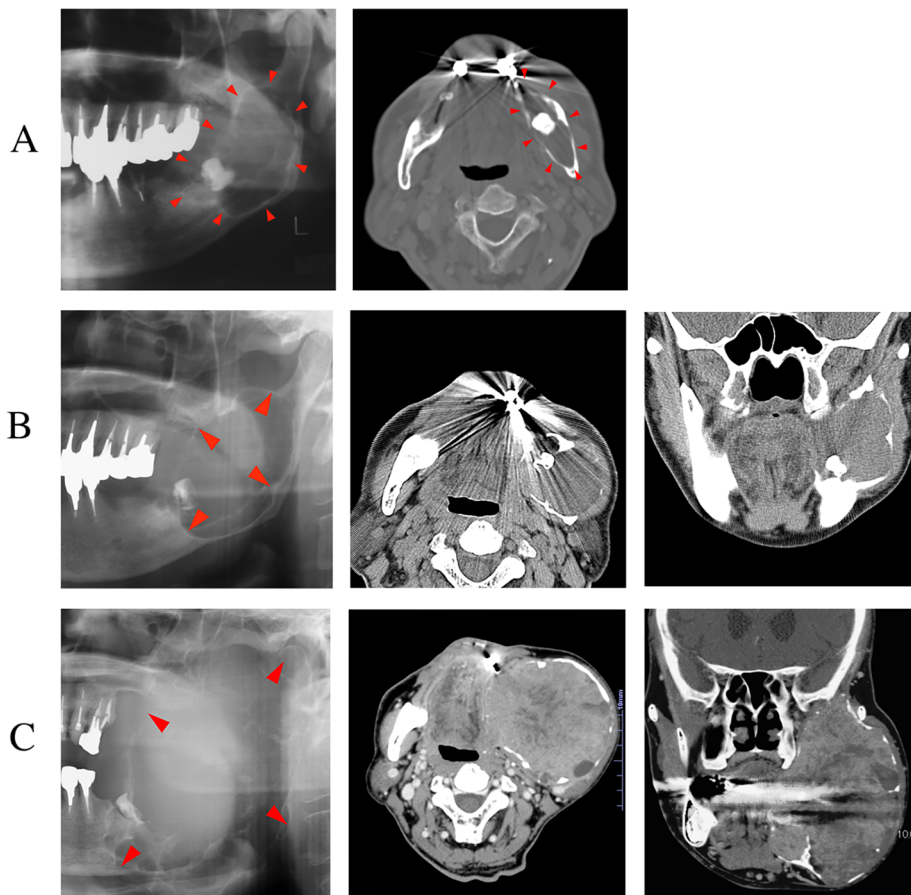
Panoramic X-rays and computed tomography show gradual expansion of the lesion in the retromolar to ascending ramus region. (A) In 2002, a multilocular radiolucent area has expanded in the left ascending ramus, with root resorption. (B) In 2004 (left image) and 2005 (middle and right image), further expansion of the multilocular lesion in the retromolar to ascending ramus region is apparent. (C) In 2009, the lesion has expanded past the ascending ramus and is approaching the skull base.
